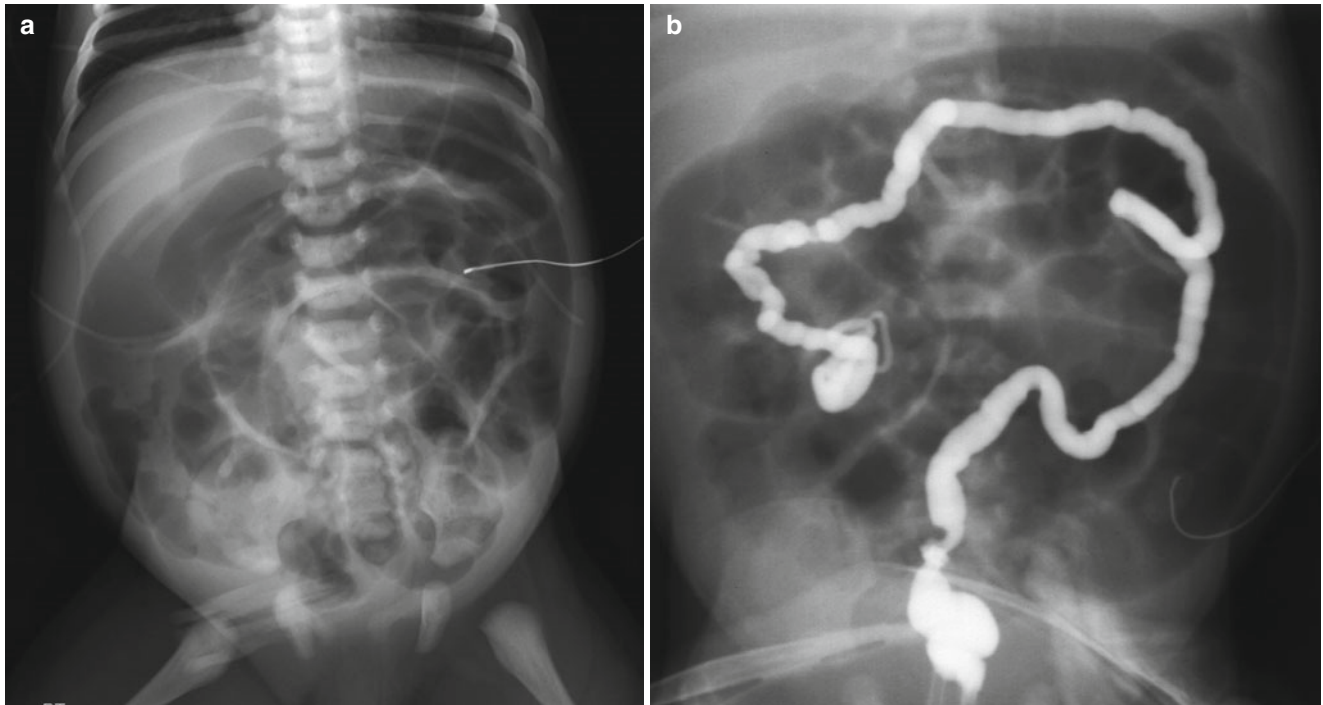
Meconium ileus in a 1-day-old full-term neonate with bilious vomiting and abdominal distension. (a)* Abdominal radiograph demonstrates moderately gaseous distension of the small bowel loops with mottled opacities in the bowel loops at the right lower abdomen.
